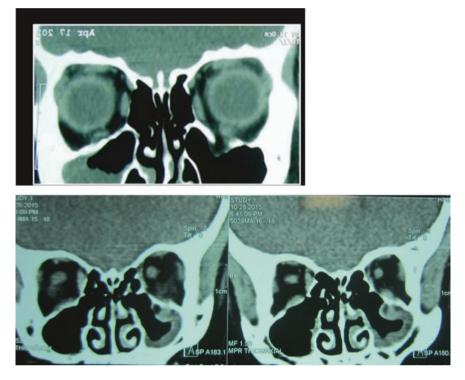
In figure a, small fracture and small fat herniation is visible in the inferior orbital wall. Fat appears hypo-dense in CT-scan very close to air in the sinuses. But the fibrous tissue appears hyper-dense. So, inferior rectus muscle seems to be entrapped there, beside the herniated fat. In figure c, fracture in the orbital floor is visible in the CT-scan
